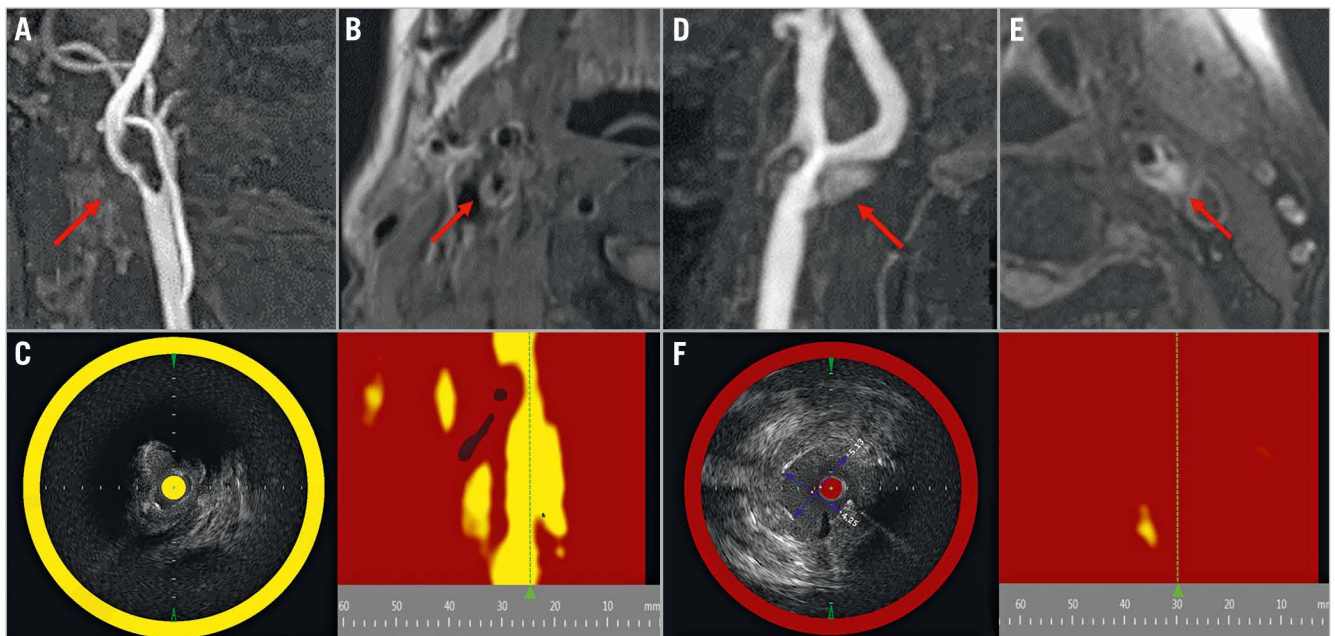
Findings from NIRS-IVUS and MRI of carotid plaques. A) Right symptomatic carotid stenosis in a 79-year-old man on TOF image (arrow). B) Plaque has slightly higher intensity on the T1-weighted image (arrow). C) NIRS-IVUS has a very high LCBI (961) at the MLA segment. This patient presented with embolic stroke and stent occlusion after CAS. D) Left asymptomatic carotid stenosis in a 72-year-old man on TOF image (arrow). E) Plaque manifests as higher intensity than adjacent muscle on the T1-weighted image (arrow). F) NIRS-IVUS reveals very low LCBI (111) at the MLA segment. Embolic events did not occur after CAS in this patient. CAS: carotid artery stenting; IVUS: intravascular ultrasound; LCBI: lipid core burden index; MLA: minimal lumen area; MRA: magnetic resonance angiography; MRI: magnetic resonance imaging; NIRS: near-infrared spectroscopy; TOF: time-of-flight
